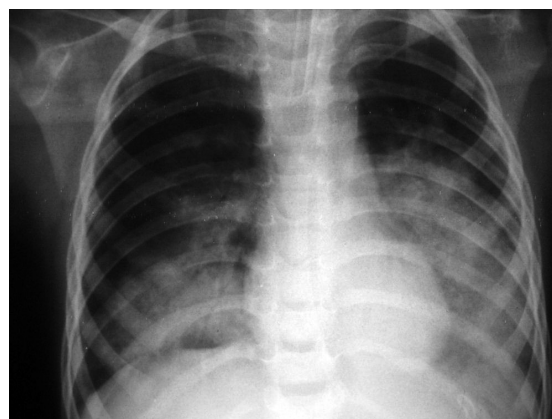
Chest radiograph shows bilateral alveolar consolidations at the lower lobes, predominantly in the left lung.
